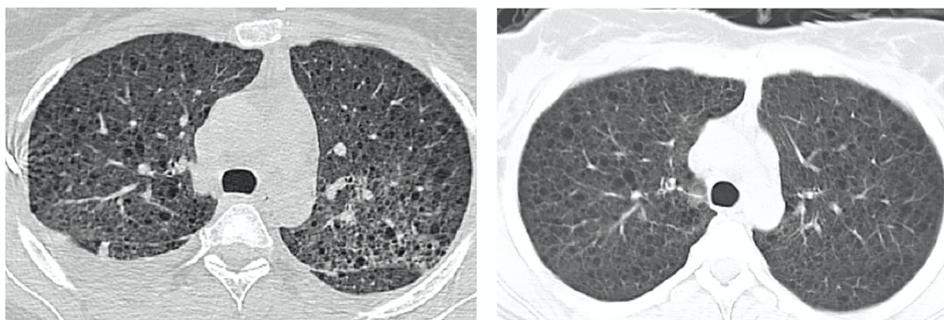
In the Left figure, axial HRCT (high-resolution CT scan) at the upper lung level reveals multiple thin wall gas-filled cystic lesions in both lungs. The intervening lung parenchyma appears hazy, and the main fissures and interlobular septa are slightly apparent, suggestive of interstitial pulmonary edema (left is more than right side (L>R)). Bilateral pleural effusion is seen (proved to be chyloous). The right image shows follow-up a few months after treatment with sirolimus. Although the pulmonary edema and pleural effusion are being resolved, the cystic lesions persist.
